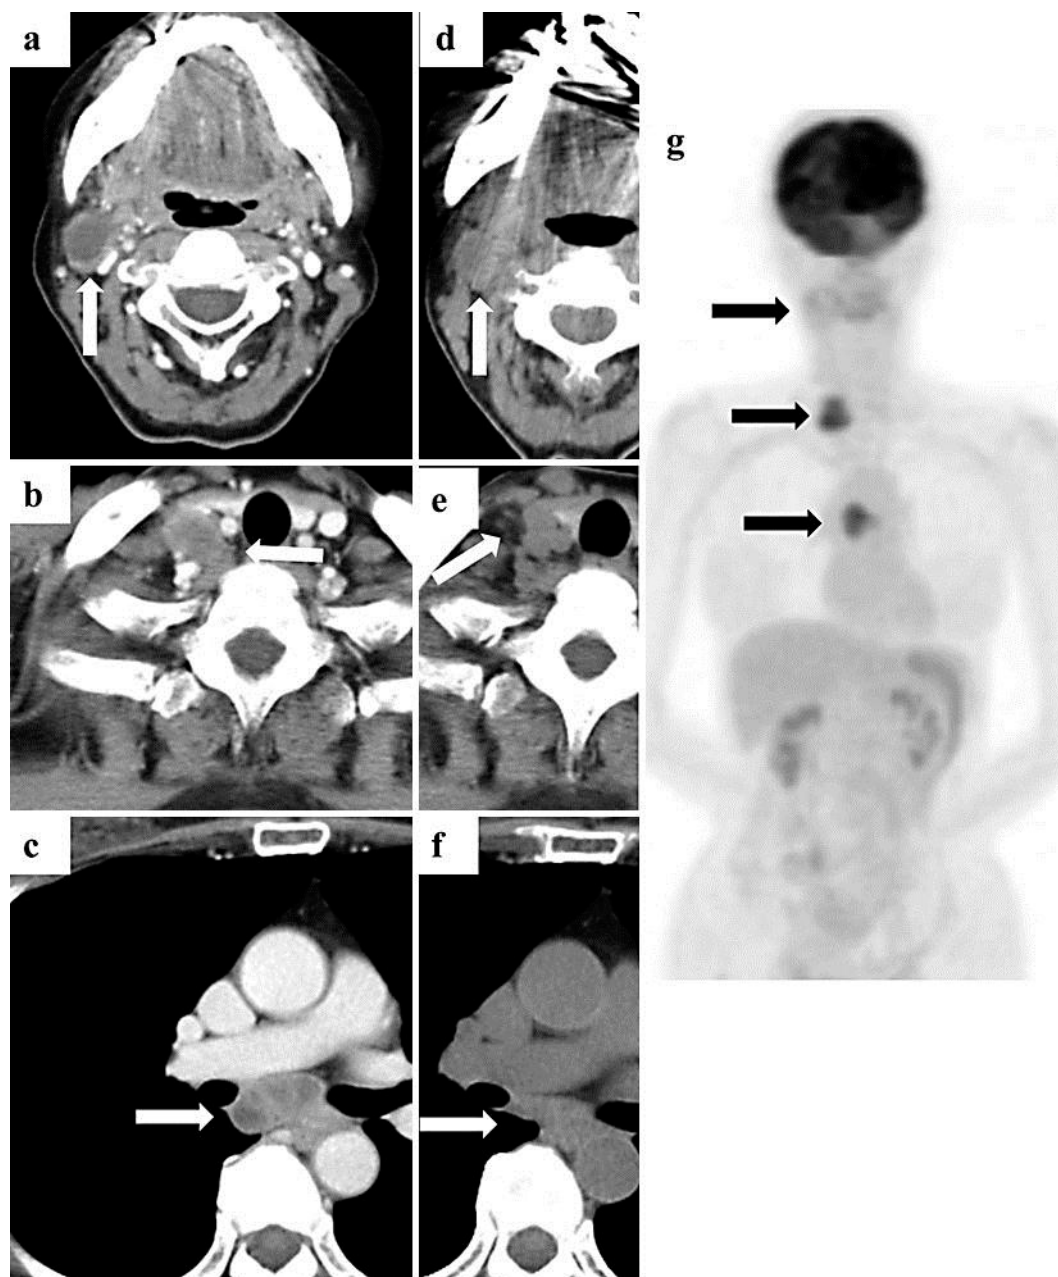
Chest CT on admission (a–c) and on day 19 (d–f) of the chemotherapy course. a, d Right submandibular lymph node (arrows). b, e Right infraclavicular lymph node (arrows). c, f Subcarinal lymph node (arrows). g FDG positron emission tomography highlighting the above-mentioned lymph nodes (arrows) on admission.
